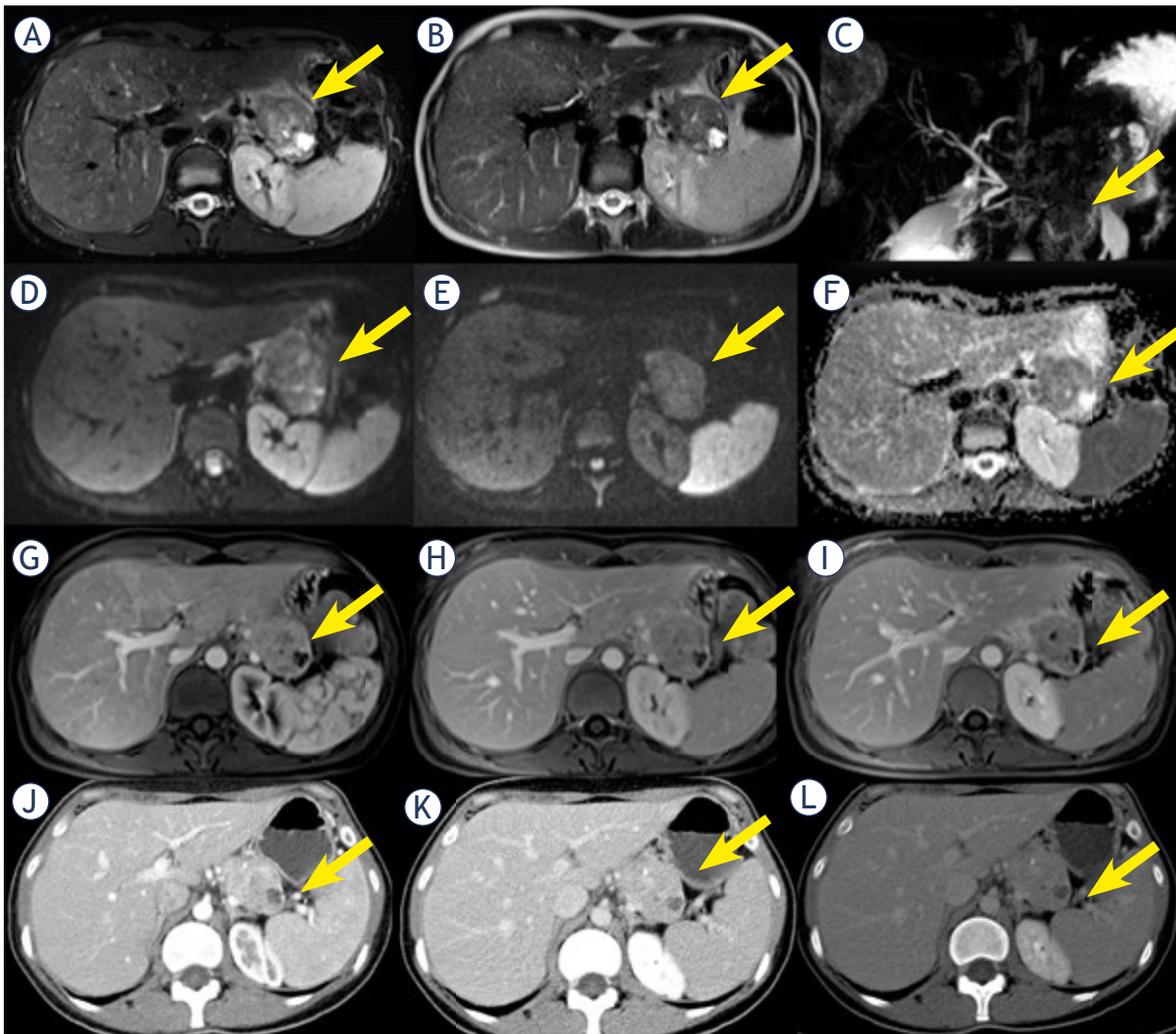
A 29 yrs old female with p-Net of pancreatic tail. The lesion shows inhomogeneous signal with cystic component (arrow) on T2-W sequences (A, B). MR cholangiopancreatography (C) sequence show its relation to the pancreatic duct and the main bile duct (arrow). The lesion shows restricted diffusion (D, E, F) and inhomogeneous contrast enhancement during arterial (G, J), venus (H, K) and late (I, L) phase as in MR as in CT (arrow).
